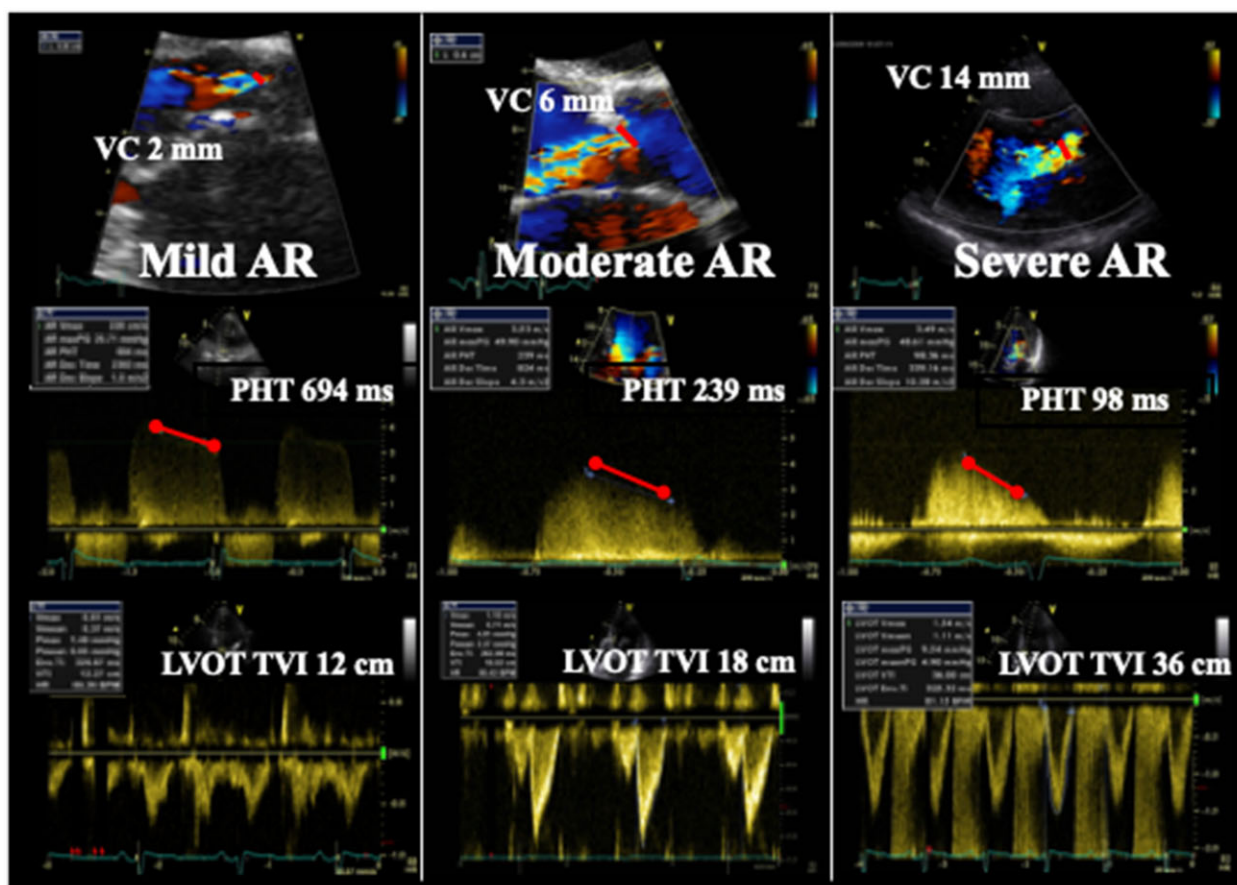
Three examples of AR are provided, all taken from the parasternal long-axis view using colour Doppler (top) and from the apical five-chamber view using continuous wave Doppler (mid). The vena contracta (VC) increases with the severity of AR. The pressure half-time (PHT) decreases with more severe AR whereas the left ventricular outflow time velocity (LVOT TVI) integral increases.
